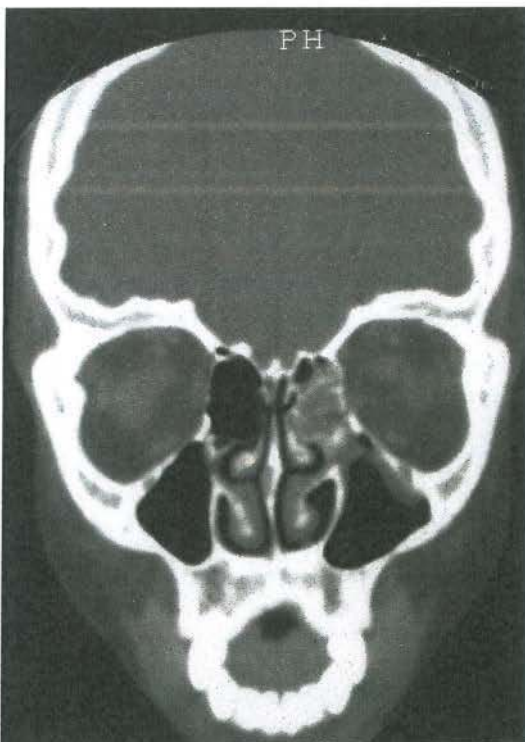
Coronal CT scan following repair of a right floor blow-out fracture with synthetic material
